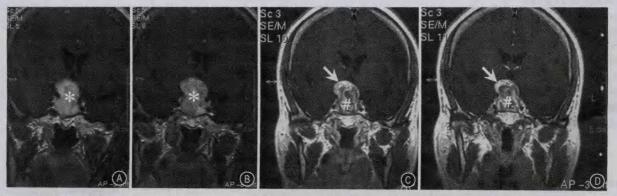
Contrast MRI of a case with tumor volume of more than 8 cm³ with Knosp grade III and Hardy's grade C. A and B: Preoperative contrast MRI coronal images. Asterisk symbol (*) shows pituitary macroadenoma. C and D: Postoperative contrast MRI coronal images. Arrow shows residual tumor in suprasellar region. Pound symbol (#) shows postoperative clots with gelatin sponges.
